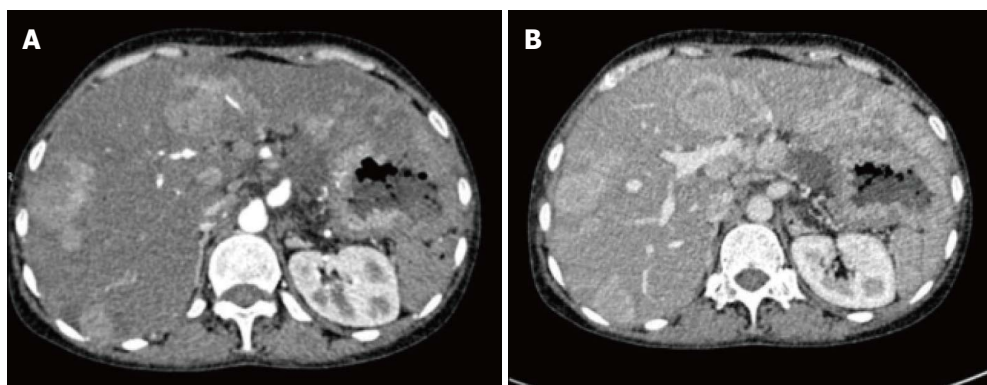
Arterial (A) and venous (B) phases of multiphase contrast enhanced axial computed tomography images showing multiple arterial enhancing focal lesions in liver with no significant wash out in venous phase.
